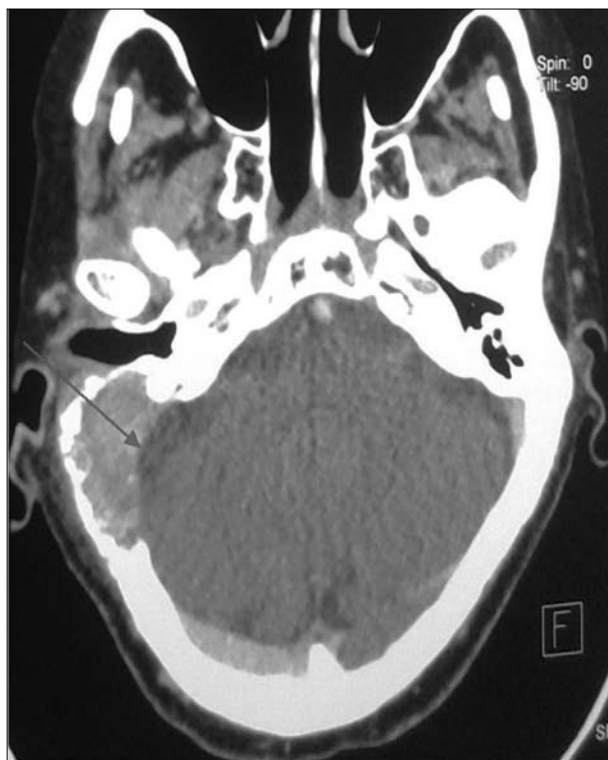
Computed tomography scan: osteolytic tumor of the right temporal bone with extension into the parietal bone and soft-tissue. Arrow shows compressive effect on the middle temporal gyrus of the brain.
